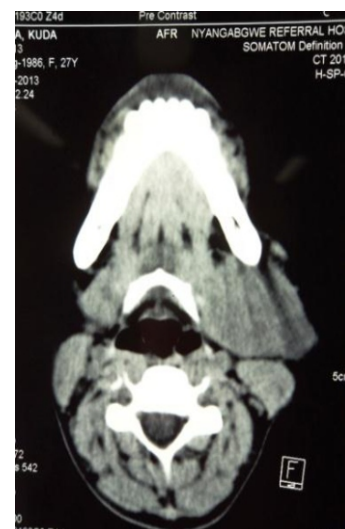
CT scan of submandibular region with well defined radiolucency
